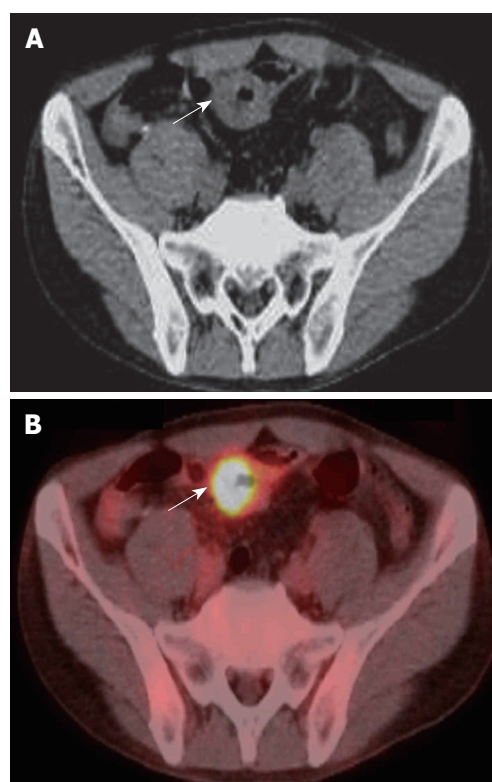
PET/CT findings. A: Wall thickening of a part of ileum (arrow). B: PET/CT showed ¹⁸F-FDG accumulation in the site of wall thickening of ileum (arrow).
